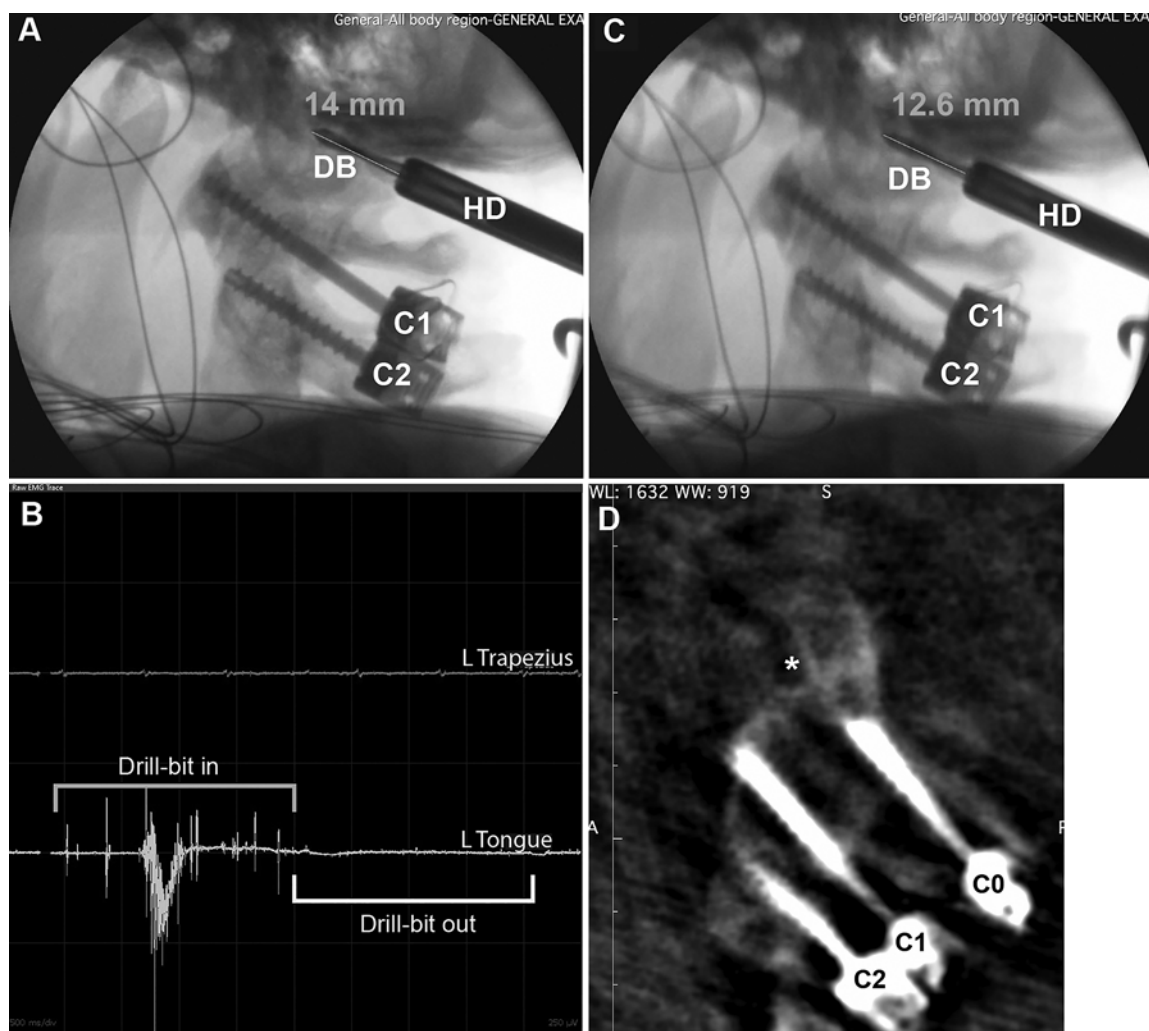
Intraoperative fluoroscopy and CT images of the instrumentation during craniocervical fusion supplemented by tongue EMG. A: Fluoroscopy showing the position of a drill bit when a burst of tongue EMG occurred (B; gray bracket). C: Fluoroscopy showing the position of a drill bit after a 1.4-mm backing out, resulting in cessation of EMG activity (B; white bracket). The screw was carefully inserted under EMG monitoring, bearing in mind the above information. D: Intraoperative CT, sagittal view, showing the final position of the screw after repositioning the craniocervical junction in extraction and mild extension. Asterisk designates hypoglossal canal. C0 = condylar screw; C1 = lateral mass C1 screw; C2 = pedicle C2 screw; DB = drill bit; HD = hand drill.
